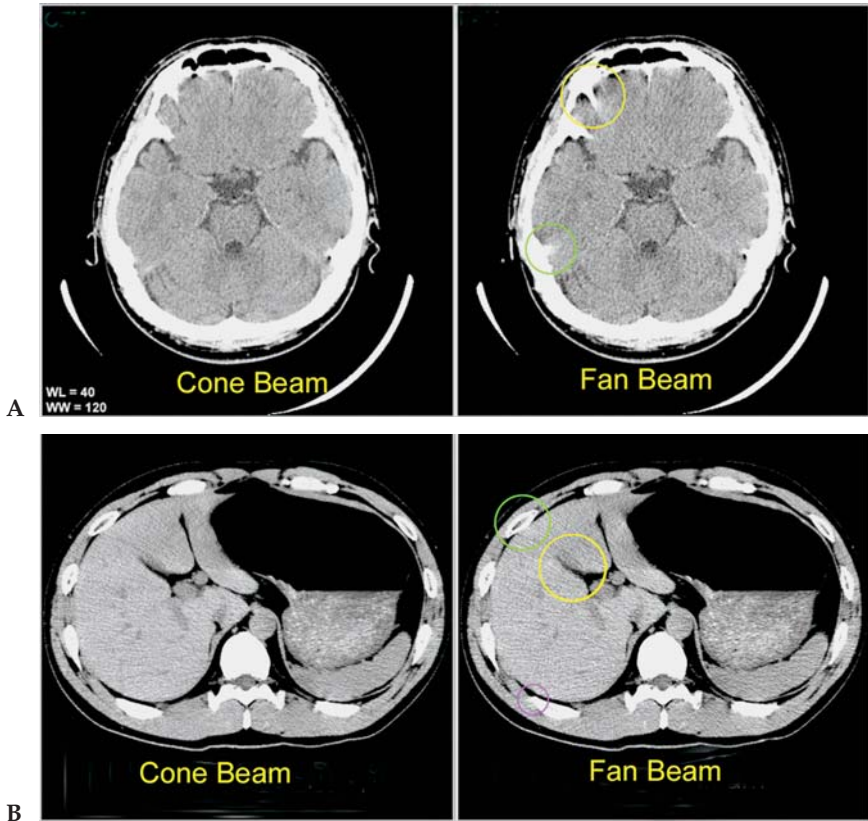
Reconstruction artifacts. (A and B) Brain and abdomen CT images reconstructed with two different algorithms (cone beam and fan beam approximation). Note the more pronounced artifacts with the non-cone beam reconstruction. Windmill and streak artifacts are most pronounced at the periphery, best noted involving the skull and ribs. Note also the blurring of the liver margin (yellow circle). (Courtesy of Ilmar A. Hein, PhD.)
